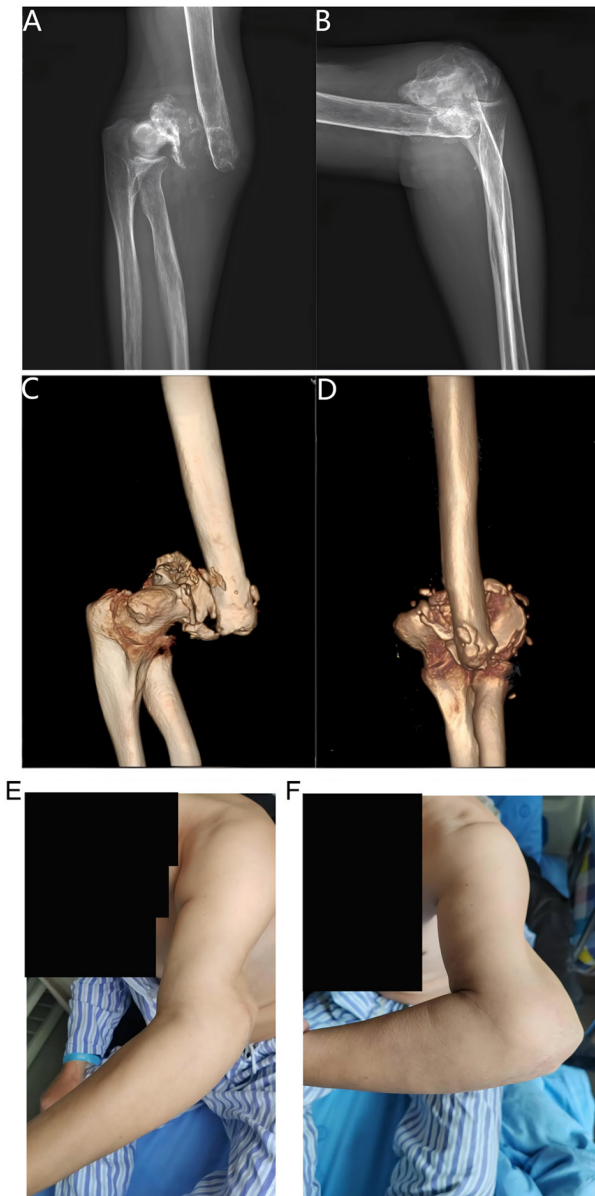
(A) Preoperative X-ray oblique view image; (B) preoperative X-ray lateral view image; (C) preoperative CT 3D oblique view image; (D) preoperative CT 3D anteroposterior view image. (E) Preoperative elbow extension was limited to -25° ; (F) Preoperative active elbow flexion range was 25° - 90° .
